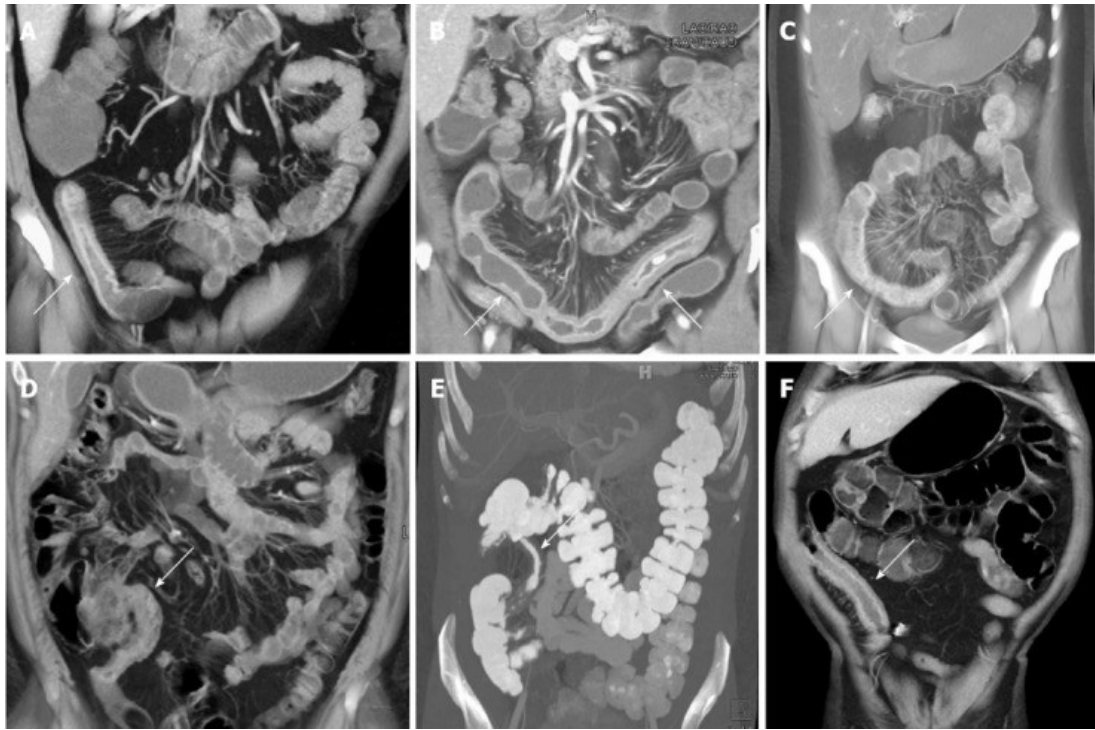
Examples of active CD manifestations in CT. A: wall thickening and mucosal hyperemia encompassing a segment of ileum (arrow). B: long segment of markedly thickened inflamed bowel in the pelvis (arrows). C: an acutely inflamed loop of colon (arrow). D: thickening and mucosal hyperemia of the terminal ileum. E: thickening of an intermediate length segment of terminal ileum (arrow); F: marked thickening, mucosal hyperemia, and adjacent vasa recta engorgement of the neo-terminal ileum (arrow) (Guglielmo et al., 2020)
